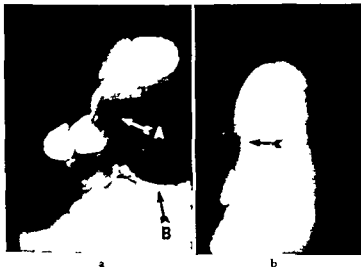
Pancreatic cyst *a* Anteroposterior view A pressure defect is shown on the curvature of the stomach at arrow A. Note the displacement of the duodenojejunal angle with a pressure defect of the first segment of jejunum at arrow B *b* Left lateral position showing an anterior displacement of the stomach. (Courtesy of Dr S Brown.) (Feldman, Clinical Roentgenology of the Digestive Tract, 3rd ed. Williams & Wilkins.)
